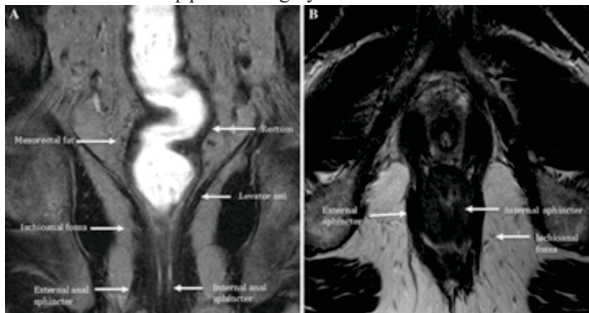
Normal anatomy of the rectum and anus on MRI.
